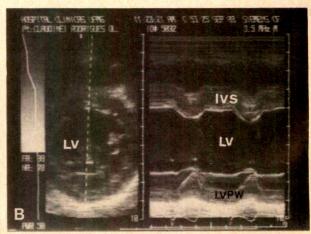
M-mode and 2-dimensional (parasternal short-axis) echocardiograms recorded in patient 1. A, echocardiogram recorded 3 days after scorpion sting showing hypokinesia of interventricular septum and left ventricular posterior wall. B, echocardiogram recorded 20 days after sting showing improvement of interventricular septum and left ventricular posterior wall motility. IVS = interventricular septum; LV = left ventricle; LVPW = left ventricular posterior wall.
